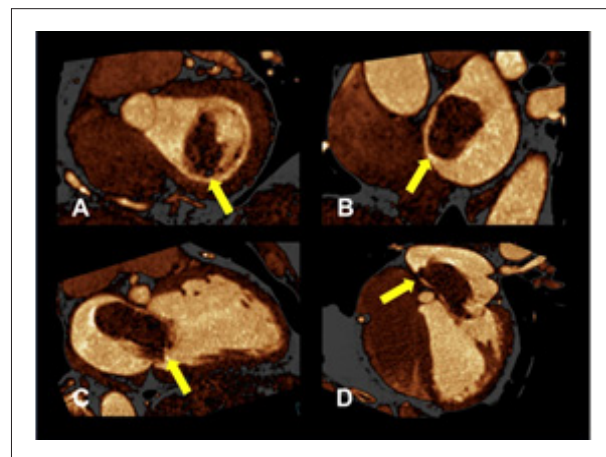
Cardiac computed tomography from a 58-year-old male patient evidencing myxoma on right and left atria (arrows). A,B) Short axis images of the left atrium revealing tumor protrusion into the mitral valve, partially blocking the left ventricular inflow tract. C) Two-chamber image showing the size of the mass in its larger axis. D) Four-chamber image of the heart in which is possible to observe a tumor pedicle adhered to the interatrial septum and the relationship between the mass and the mitral valve orifice. Image Courtesy of Dr. Tiago Augusto Magalhães.
